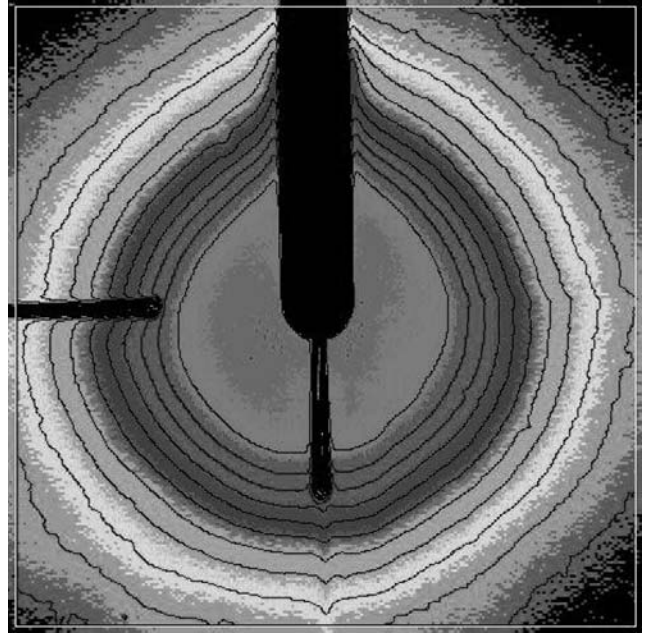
Isodose curves for the INTRABEAM X-ray device. It can be seen that the tip of the probe is the center of the X-ray source and that the source is nearly isotropic in intensity except in the backward direction close to the tube.
